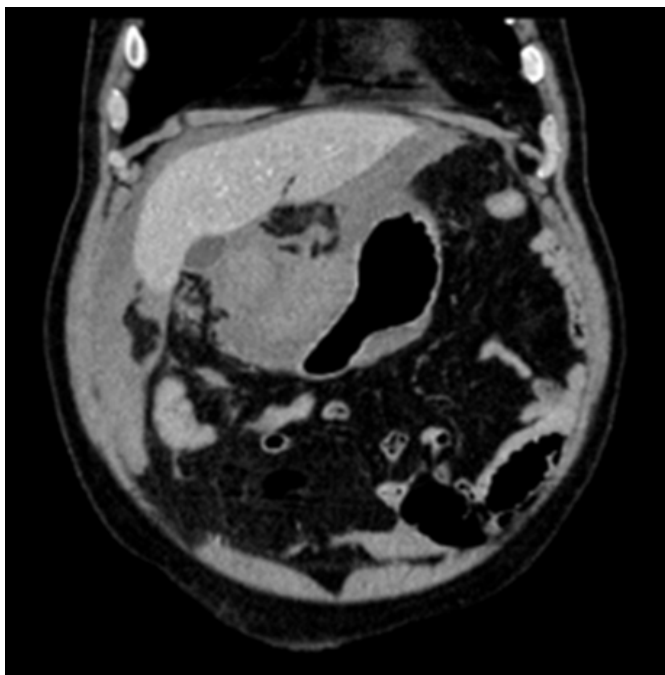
Axial section in native CT scan showing a massive mass situated in front of the stomach, occupying the subhepatic region.
